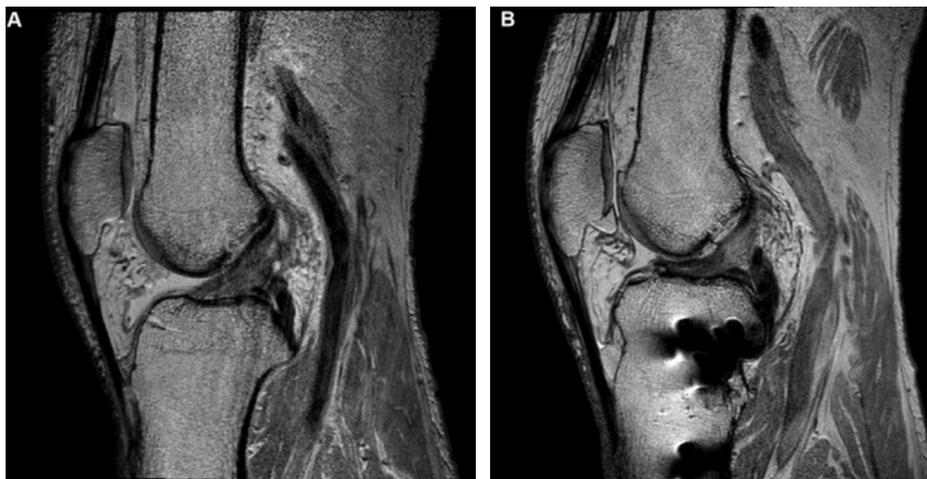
Example of postoperative morphological ACL change: change of ACL fiber shape (right side of knee) (A) preoperative sagittal MRI image (B), postoperative sagittal MRI image.
